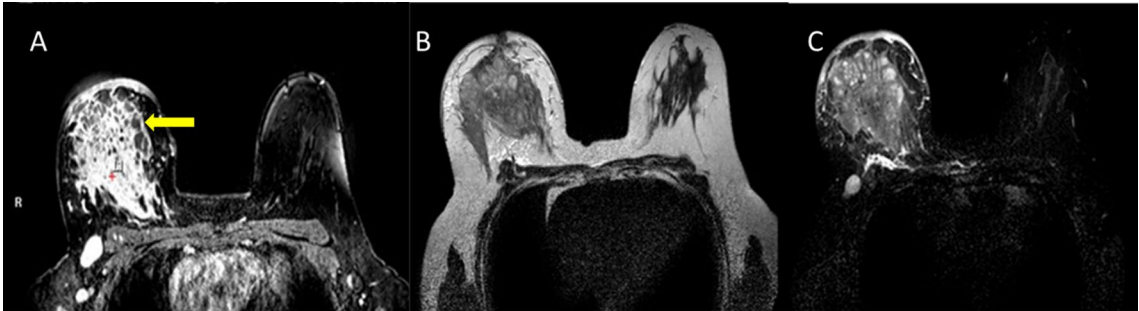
A 43-year-old female with right breast induration and tenderness, under antibiotic treatment for one month with no apparent amelioration of the condition. Pathology revealed benign pathology; non-specific granulomatous mastitis with multifocal suppuration and chronic abscess formations. A Axial post-contrast dynamic MRI series reveals suspicious intense heterogeneous and clustered ring (arrow) non-mass enhancement (false positive). B and C Axial T2 weighted and STIR MRI images show diffuse breast involvement by an ill-defined complex process with bright to intermediate signal intensity with multiple tiny abscess cavities (true negative)
